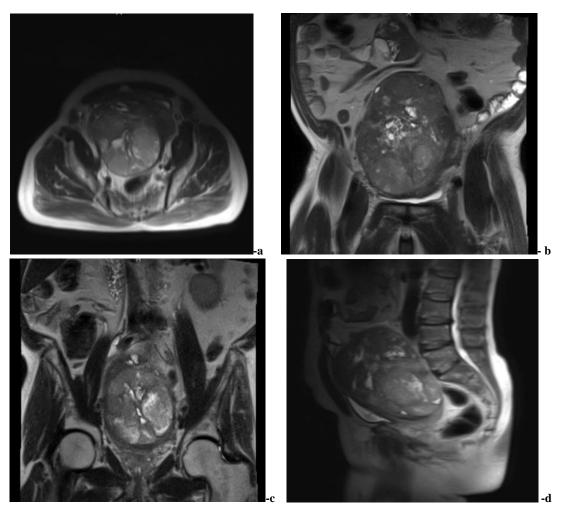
MRI showed Large well-circumscribed fairly solid enhancing mass
